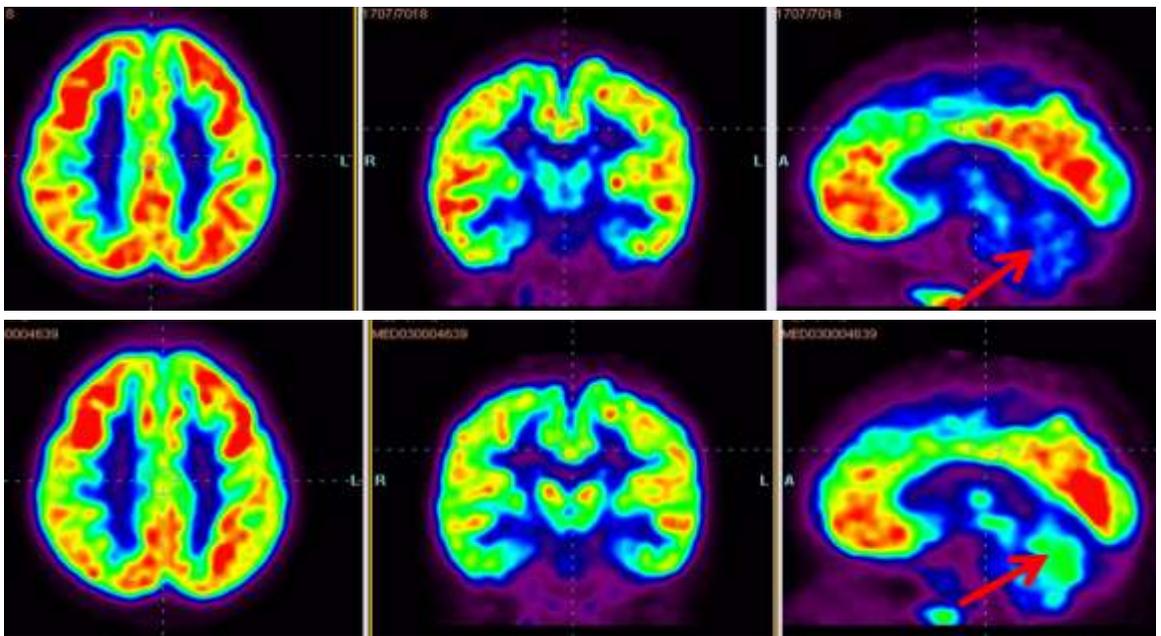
Comparative PET CT scans of an autism patient performed before and 6 months after stem cell therapy. Significant improvement was observed in bilateral medial temporal cortex, thalamus and cerebellum
